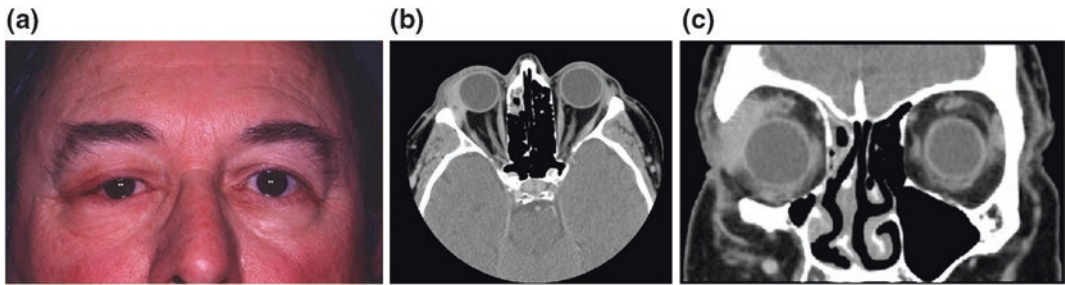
a A 63-year-old male presented with a 4-week history of right upper lid swelling, redness and discomfort on palpation over the right lacrimal gland area. A 10-day course of cephalexin was not helpful. b Axial CT scan showed uniform enlargement of the lacrimal gland with out any sign of bone erosion. c Coronal CT scan also demonstrated an enlarged lacrimal gland. A lacrimal gland biopsy confirmed non-specific inflammation involving the right lacrimal gland. The patient responded well to an 8-week tapering course of prednisone
